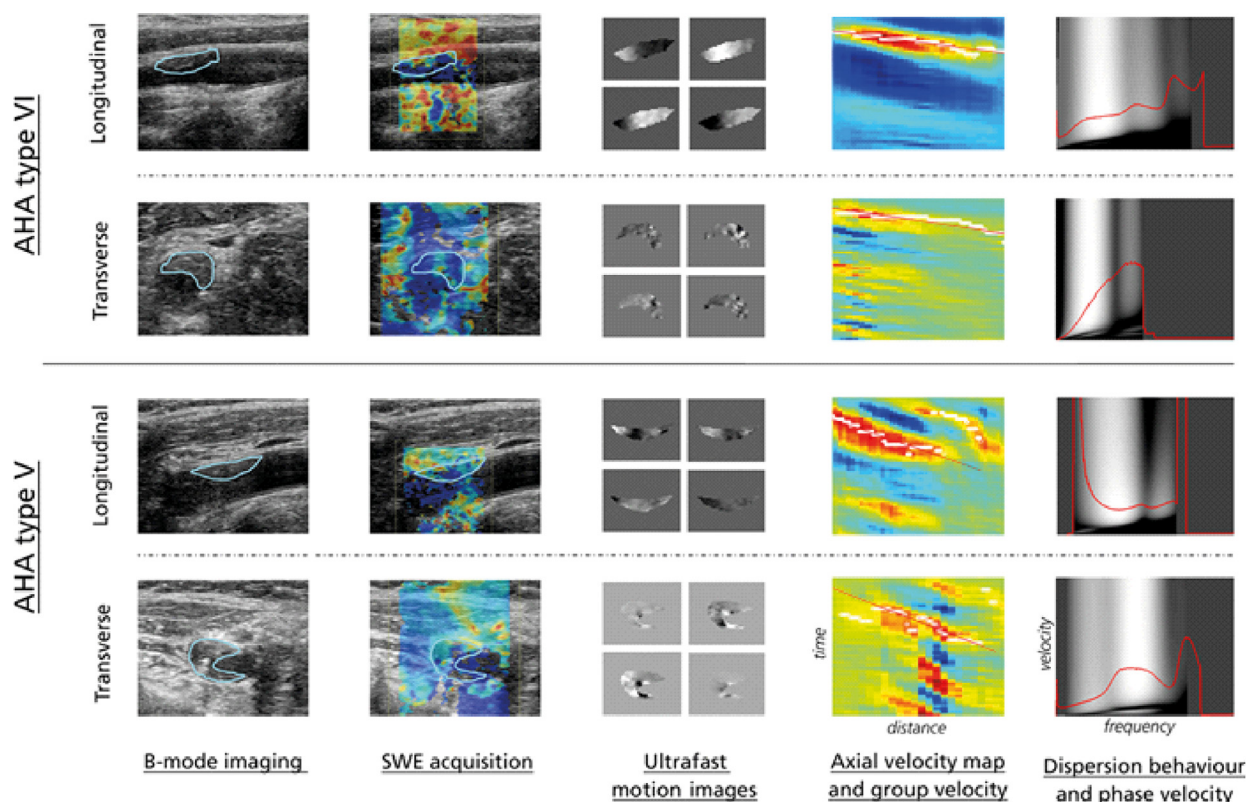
Example of group and phase velocity analysis in the longitudinal and cross-sectional imaging directions for one American Heart Association (AHA) type VI and one AHA type V plaque using the raw ultrasound data of a General Electric Logiq E9 system (GE Healthcare, Wauwatosa, WI, USA). From left to right are B-mode images of the carotid artery including the plaque, shear wave elastography (SWE) acquisition, ultrafast motion images obtained from data autocorrelation (from upper left to lower right four snapshot motion images are displayed), axial velocity map (space–time domain) with time-to-peak estimated group velocity (*red slope*) and Fourier-generated dispersion behavior and phase velocity map (velocity–frequency domain). All examples are shown over a frequency range of 0–750 Hz. (Reprinted with permission from [Marlevi et al. \[2020\]](#), published under the terms of the Creative Commons Attribution License [<http://creativecommons.org/licenses/by/4.0/>]).
